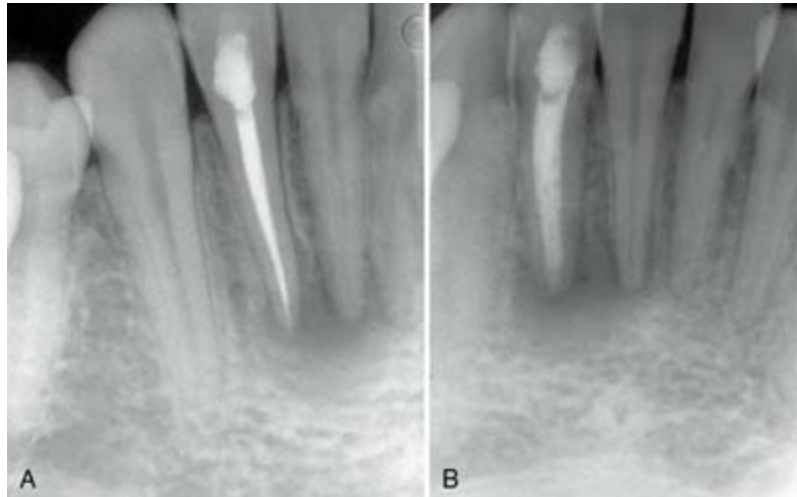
A, Posttreatment radiograph of a mandibular left lateral incisor with ostensibly adequate obturation. B, Angled view reveals voids.
